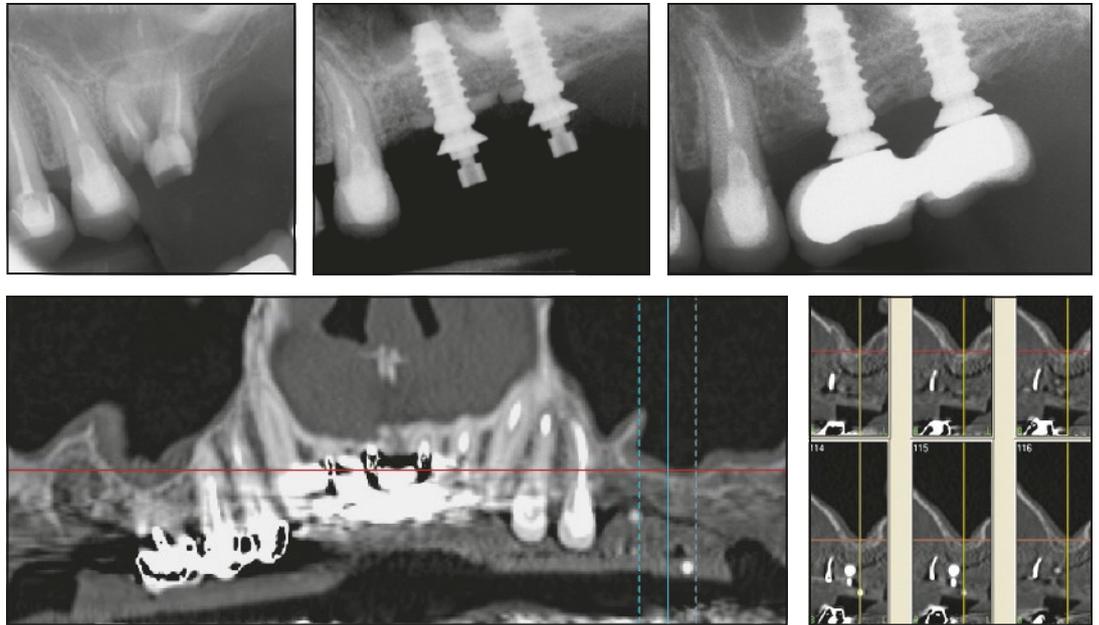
Case 2: Radiographic exams at 60-month follow-up.
